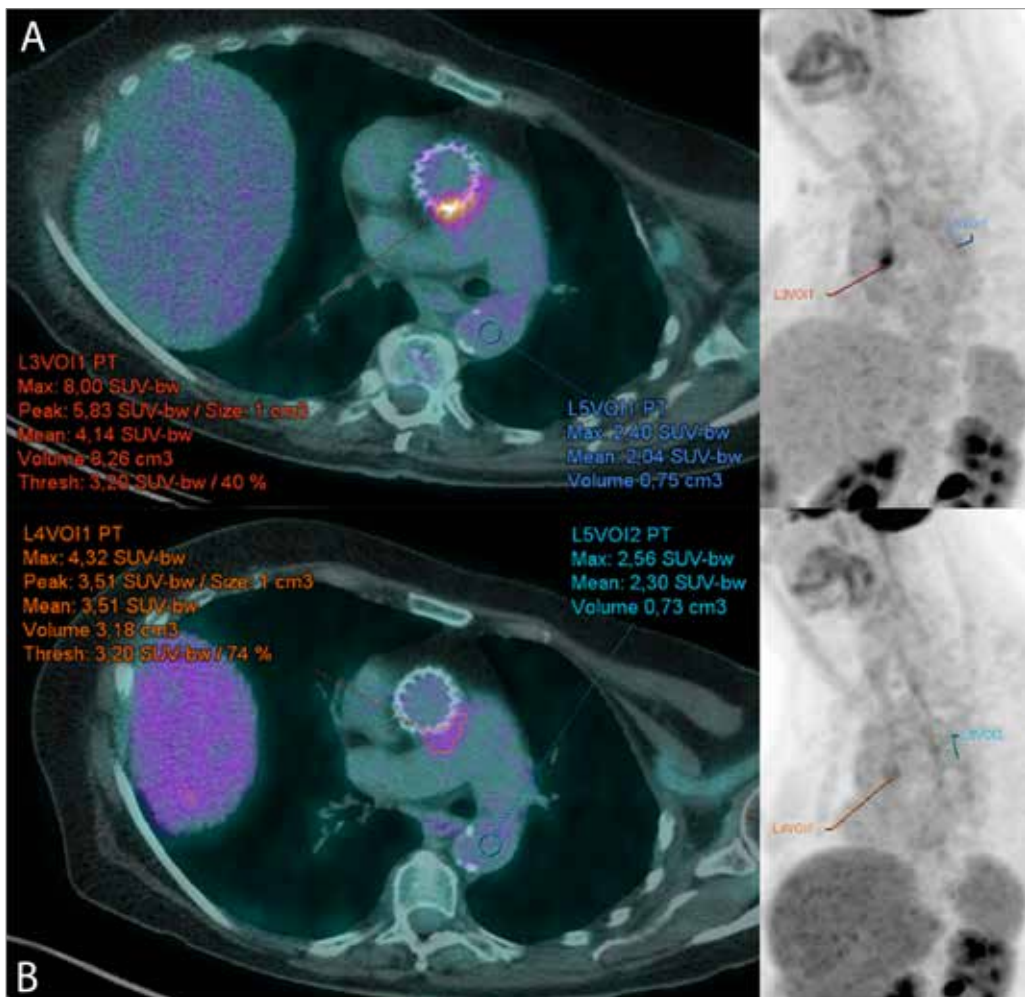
Quantitative analysis of the FDG-uptake surrounding the TAVI prosthesis. (A) Fused PET/CTA (left) and PET maximum intensity projection (right) of the first PET/CT at presentation, with an SUV_{max} of 8.00 and a SUV_{ratio} of $8.00/2.04=3.92$. (B) Follow-up PET/CTA after 6 weeks of antibiotic treatment, showing decreased FDG uptake (SUV_{max} 4.32, SUV_{ratio} 1.88).
